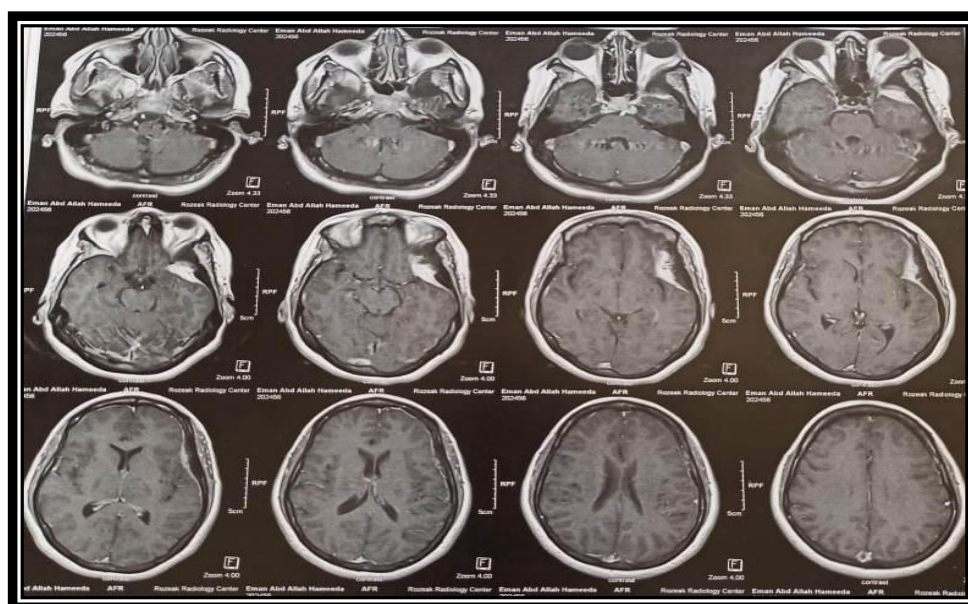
MRI brain with contrast meningioma en plaque with bony affection
